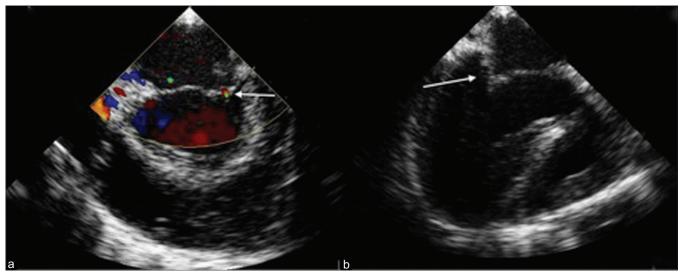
(a) Post-repair, Intra-operative Trans-Esophageal Echocardiogram (TEE) showing minimal Mitral Regurgitation. (b) Post-repair, Intra-operative Trans-Esophageal Echocardiogram (TEE) showing the newly intact posterior leaflet of the Mitral valve
